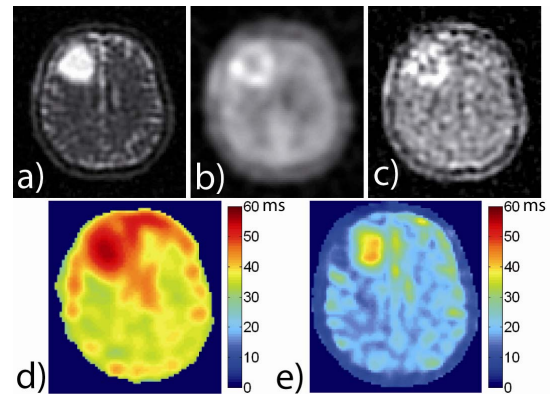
Images of an oligodendroglioma patient after surgery. a) ^{23}Na -conc. b) ^{23}Na -FLAIR (TE/TR = 0.65/185 ms; TI = 37 ms; resolution: (5.5 mm)³; Hamming-filtering; $T_{AQ} = 9$ min 52 s). c) Subtracted image of the ^{23}Na -DE-sequence. d) ^{23}Na - T_1 -map; e) ^{23}Na - T_2^* -map.
